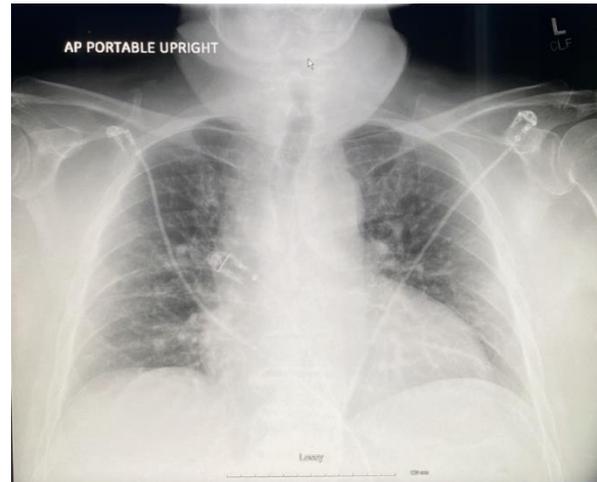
Chest X-ray indicating heart enlargement.
